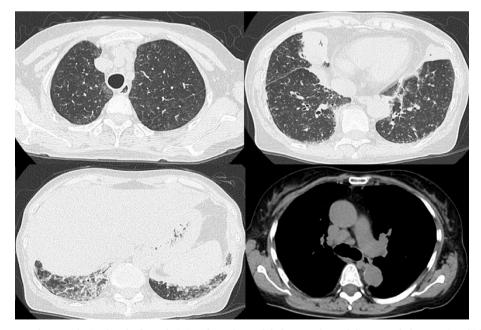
Chest computed tomography scan obtained at the first admission showed centrilobular granular nodules, ground glass opacity, thickening of the interlobular septa predominantly in the lower lung, consolidation in the right middle lobe and left lingula segment and swelling of the #4R lymph node.
